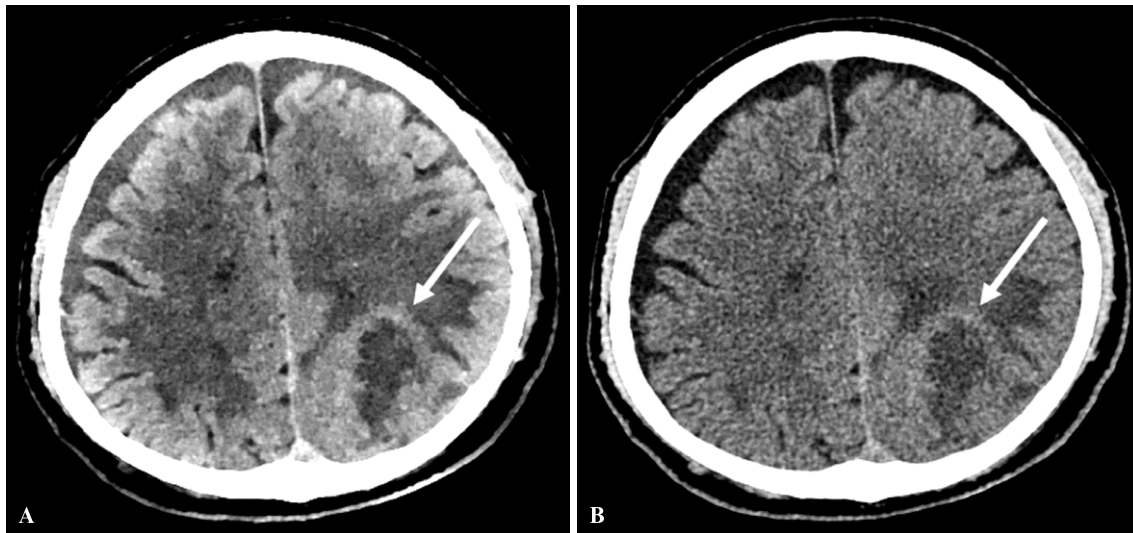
A 75-year-old man (body weight, 75.6 kg) with suspected intracranial disease underwent brain CT.
